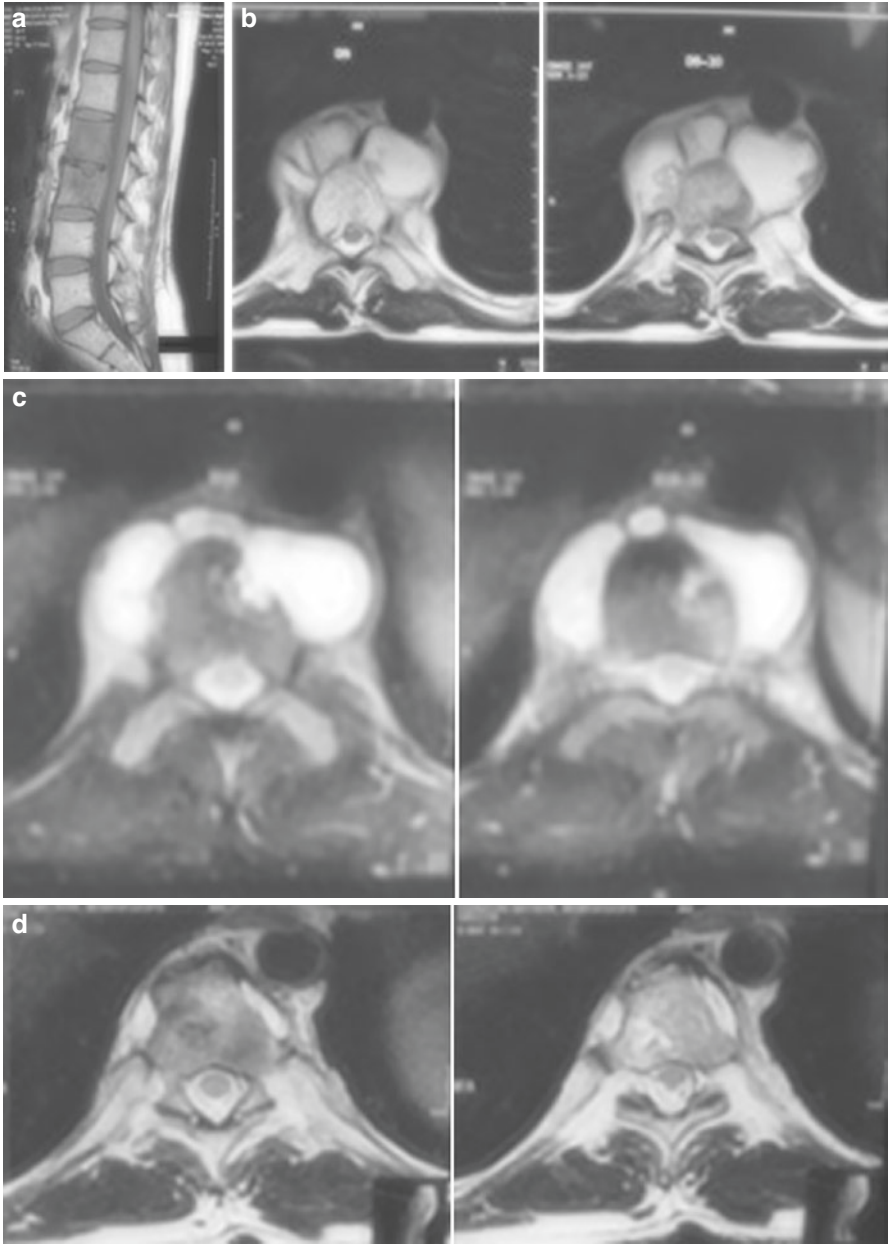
(a) MRI LS spine showing worsening at 2 months after starting primary AKT for biopsy proven TB spine despite of clinical improvement. (b) MRI LS spine showing paravertebral abscess at 6 months after starting primary AKT despite patient clinically healed. (c) MRI LS spine showing paravertebral abscess at 12 months after starting primary AKT despite patient clinically healed at 6 months of treatment. (d) Twelve months after AKT stopped despite above MRI
